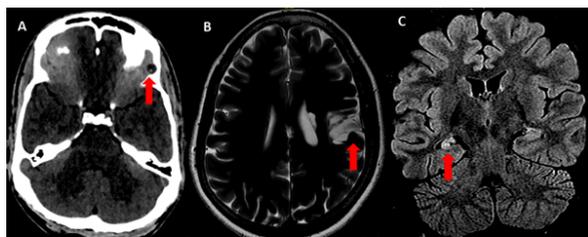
MRI Brain- A- T2 weighted axial image showing granuloma (Neurocysticercosis) in basifrontal region in 17 year old boy with focal seizure. B- Hyperintensity in T2 weighted axial image in left parietal region (gliosis) in 45 year old male. C-Right side Mesial Temporal lobe Sclerosis in a 11 year old boy
